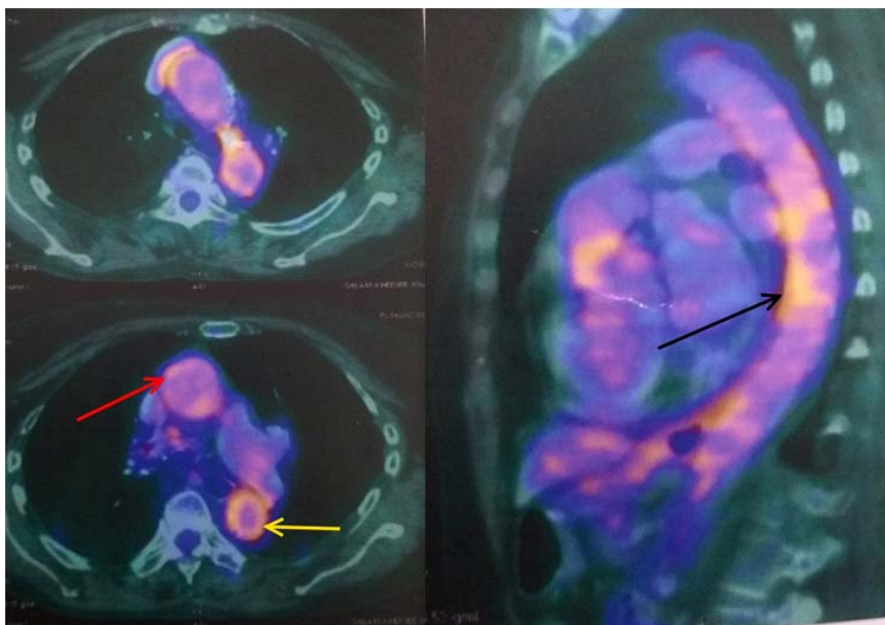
PET-CT appearance of Aortoarteritis in the patient showing wall thickening with increased FDG uptake in ascending aorta (Red arrow), descending aorta (Yellow arrow) and thoracic aorta (Black arrow)
